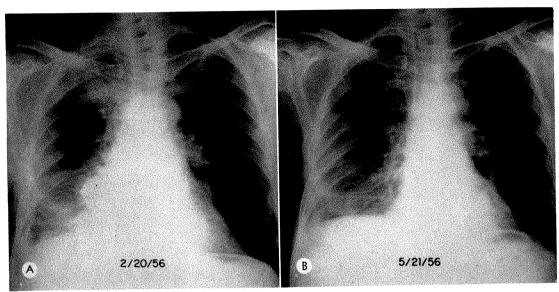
C. (A) Unresectable adenocarcinoma of right upper lung. Roentgenogram made February 20, 1956 prior to radiation therapy alone. Patient received 6,000 r tumor dose in 50 days via open port. (B) Roentgenogram made May 21, 1956, three weeks before completion of radiation therapy. Patient had a 3+ objective response and was asymptomatic 11 months. Patient died 19 months post therapy.
